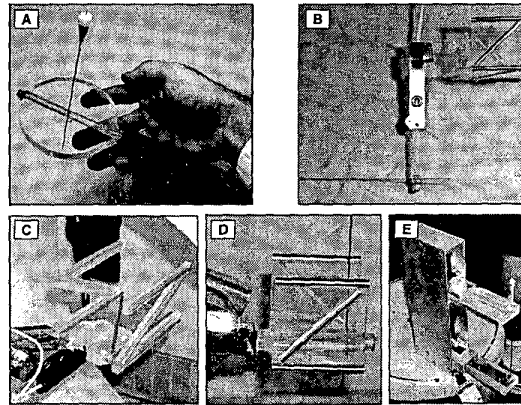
X-ray compatible needle drivers. (Stoianovici et al., in collaboration with Susil (C), Masamune (D), and Wiard (E), 1999-2001)
